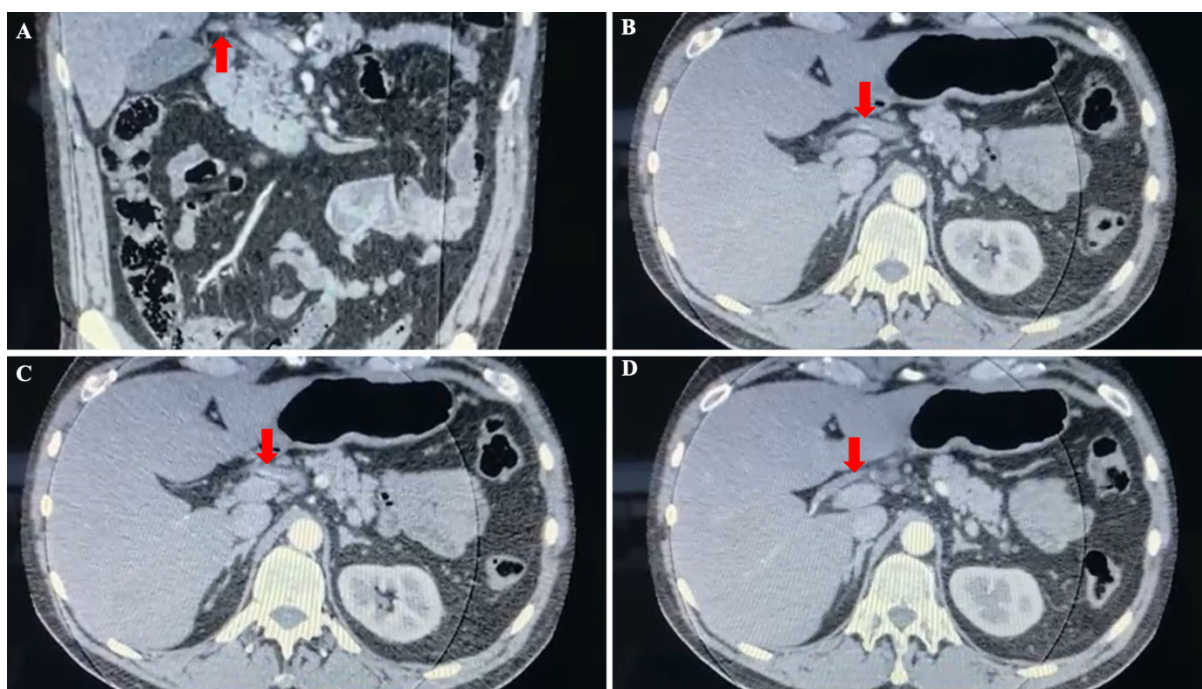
Imaging findings of hepatic artery dissection on abdominal CT angiography. The dissected segments are indicated by red arrows (A: Coronal view; B, C, D: Axial views).
